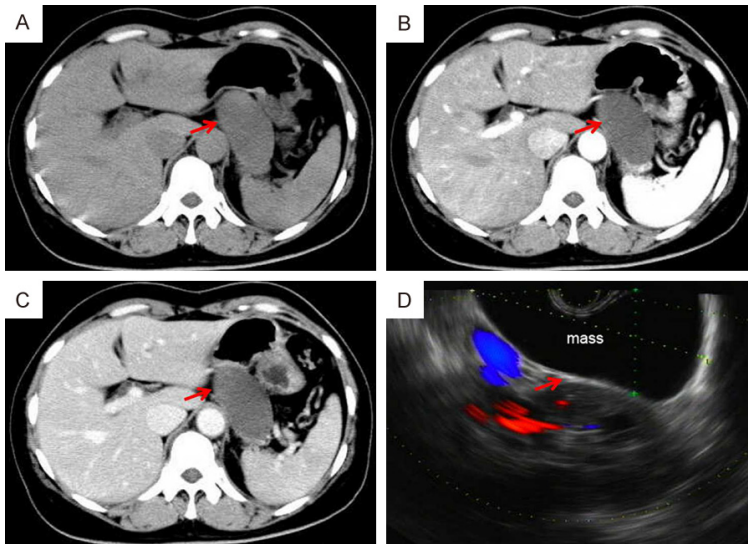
Abdominal computed tomography scan confirmed a homogeneous, low-density mass, measuring 6.3 cm×3 cm (arrows), between the stomach and body of the pancreas (A), without enhancement in the arterial phase (B) and portal phase (C). Endoscopic ultrasonography showed an anechoic cystic lesion near the body of the pancreas not connected with the pancreatic duct or the stomach wall (D).
